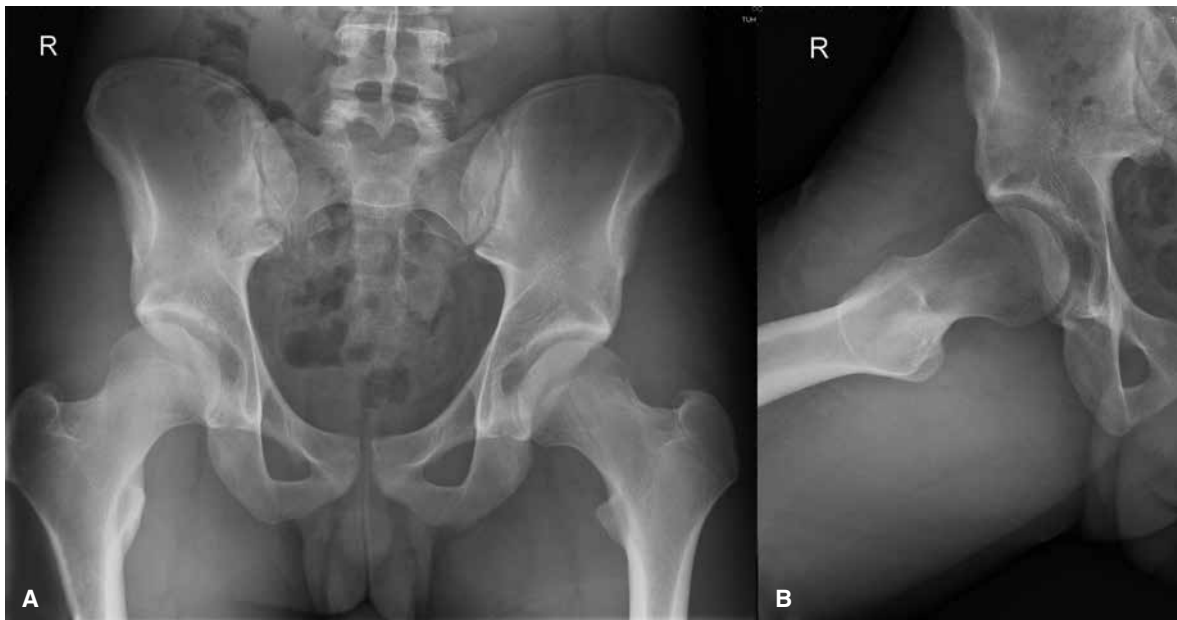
(A–B) AP Pelvis and right hip Dunn elongated neck lateral radiographs.
